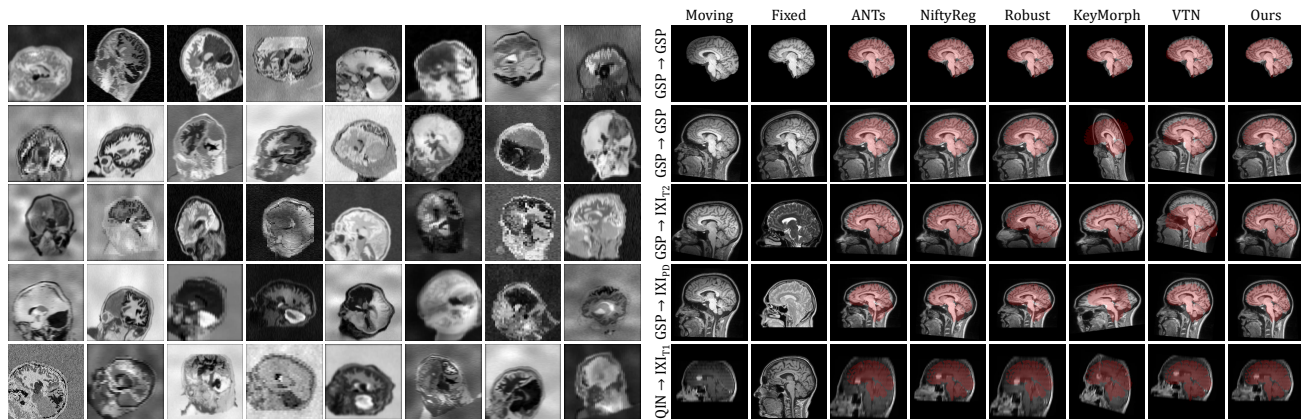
Left: synthetic training data generated from brain label maps. The images exceed the realistic range to promote network generalization across acquisition protocols. All examples are based on the same label map. In practice, we use data from several subjects. Right: representative 3D affine registration pairs showing the image moved by each method overlaid with the fixed brain mask. Each row is an example from a different dataset. Subscripts indicate MRI contrast.
